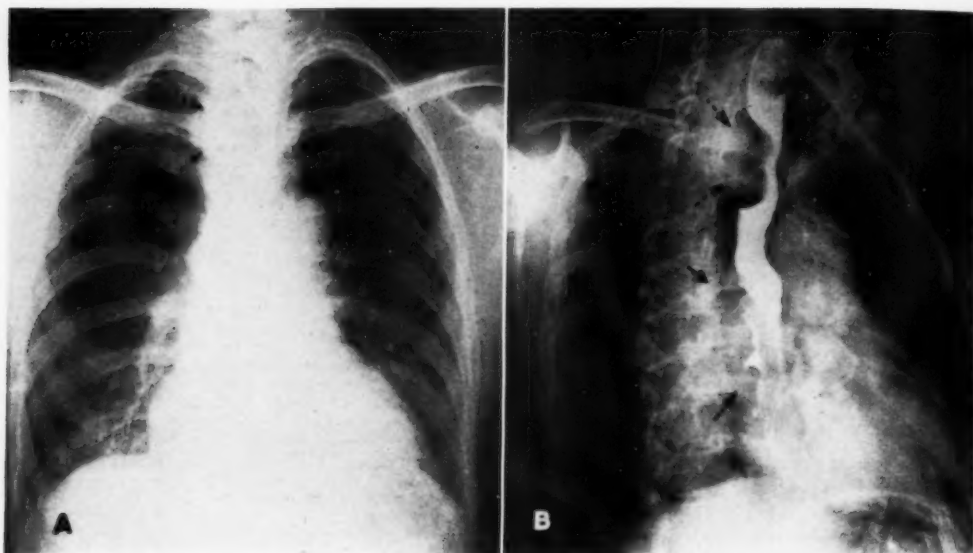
Right paratracheal lymph nodes. The patient was a 65-year-old white woman, admitted with difficulty in swallowing of eighteen months duration. Roentgen examination disclosed a large irregular tumor in the third segment of the esophagus, beginning at the level of the tracheal bifurcation and extending downward for a distance of 9 cm. (solid arrows). The extent of this tumor with its large central ulceration is well shown in the right anterior oblique projection (B). In addition, enlarged lymph nodes are seen in the right superior mediastinum. On the postero-anterior chest roentgenogram (A) these nodes, which are slightly nodular in outline (dotted arrows), are seen to indent the right lateral margin of the trachea and esophagus.
